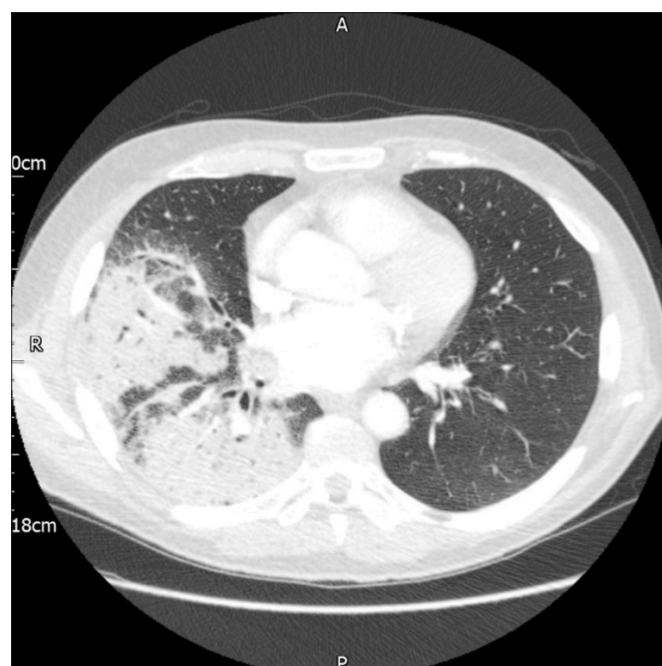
CT scan showing left Upper Lobe adenocarcinoma.
